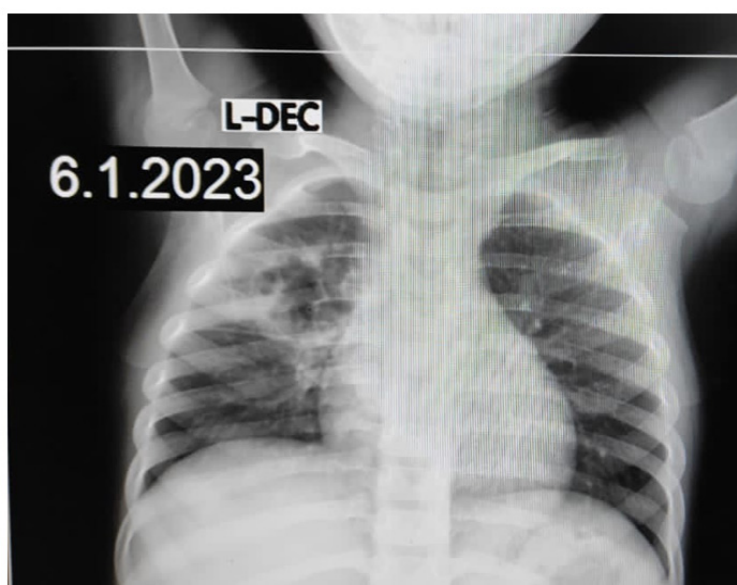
X-ray compatible with bronchopneumonic inflammatory process of slow resolution
